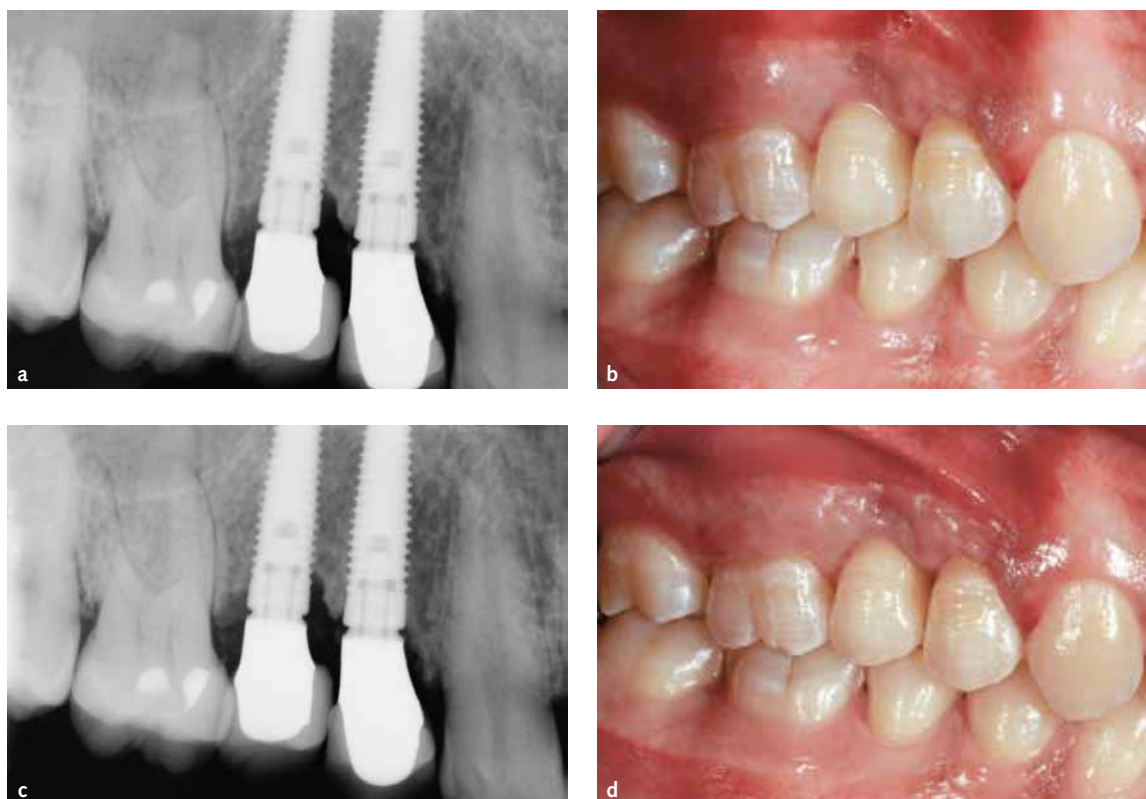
Sequence of treatment of the only complication (peri-implantitis): a) periapical radiograph 2 years after implant placement showing a bone loss up to the third thread; b) clinical situation 2 years after implant placement showing bluish discoloration of the soft tissue related to the inflammation; c) periapical radiograph at the 3-year follow-up, showing stable peri-implant bone; d) clinical situation 3 years after implant placement, showing a healthy peri-implant tissues with no sign of inflammation.
